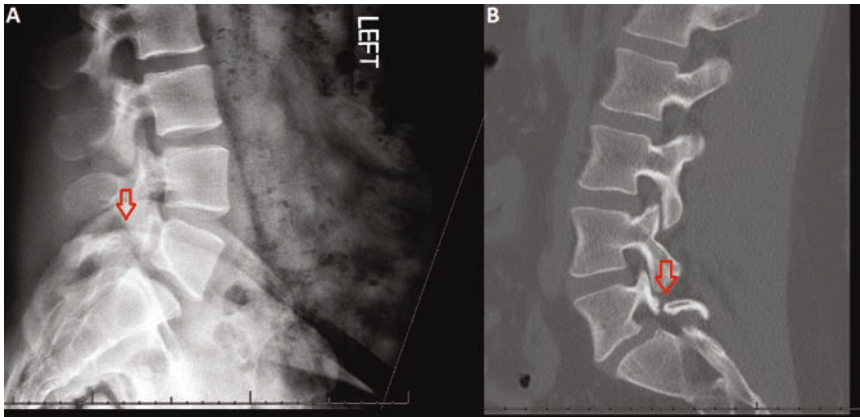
Lateral lumbar radiograph (a) and sagittal CT of the lumbar spine (b) demonstrating an L5 pars defect (arrows)
